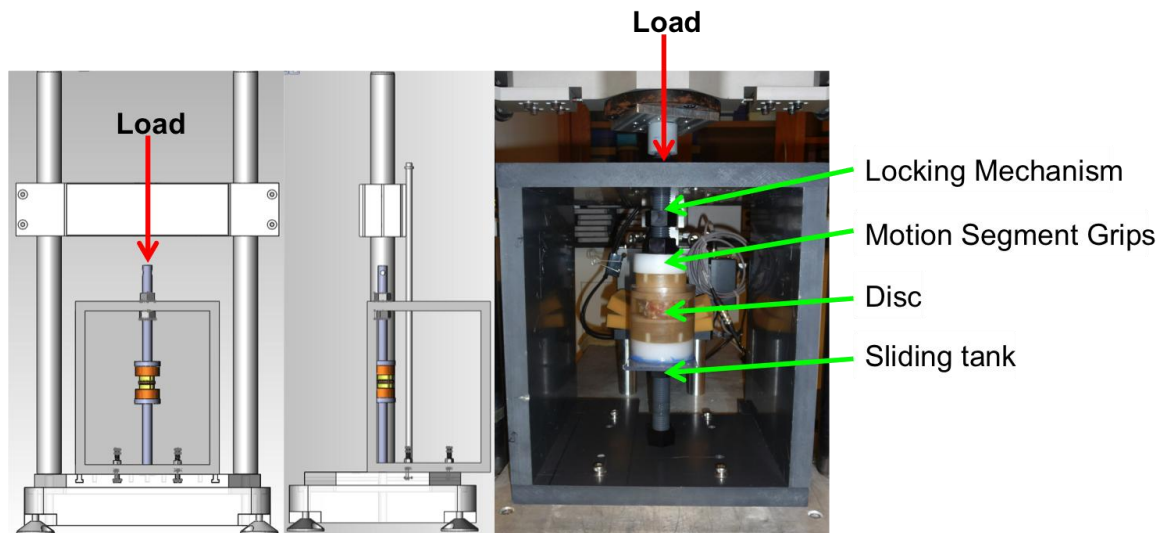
MRI loading frame integration with Instron 8874
